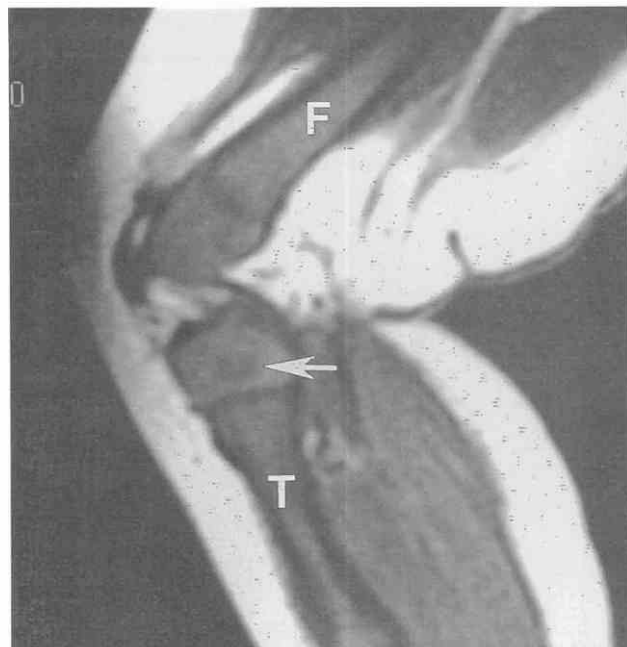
Normal bone marrow in a 9-week-old boy. Sagittal T1-weighted image (TR = 350 msec, TE = 16 msec) of the knee shows diffuse low signal intensity within metaphyseal and diaphyseal marrow, consistent with hematopoietic marrow. The proximal tibial ossification center is faintly visible (arrow). F, femur; T, tibia.
